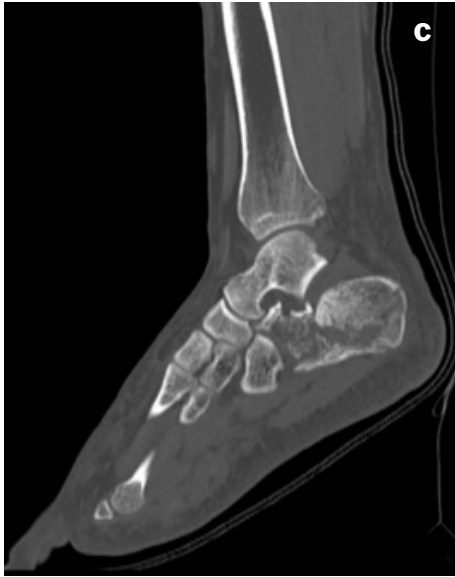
(A-C): CT Scan of fracture. A. Axial view depicting severe comminution of the posterior facet of the subtalar joint and lateral wall blowout. B. Coronal view C. Lateral view.
